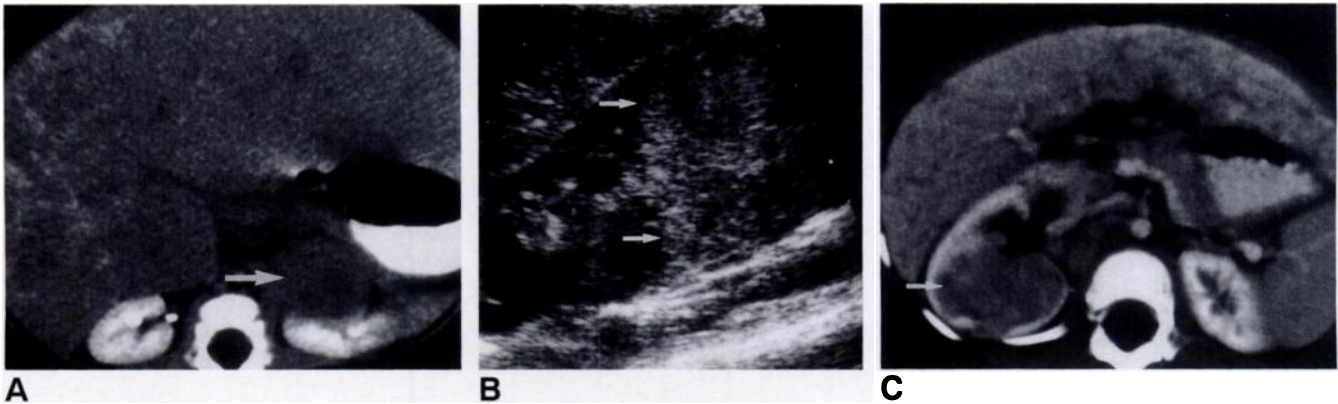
A, Contrast-enhanced CT scan shows left adrenal mass (arrow) and enlarged liver with heterogeneous attenuation consistent with diffuse metastases.
